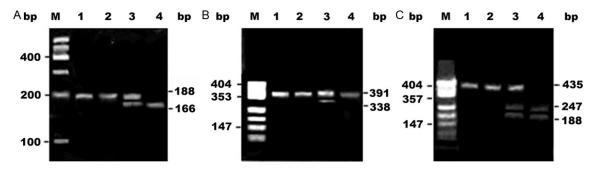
Electrophoretograms of amplified and digested PCR products of A: *MMP-2* -1306C/T, B: *MMP-2* -735C/T, and C: *MMP-9* -1562C/T. PCR products less than 100 bp were not visualized. (M: Marker; 1: PCR amplified product; 2: CC genotype; 3: CT genotype; 3: TT genotype).
